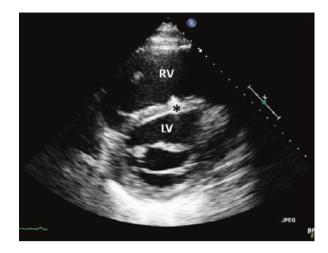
A 2-dimensional echocardiogram image showing dilation of the right ventricle (*RV*) and flattening of the intraventricular septum (*) due to right ventricular pressure and volume overload. *LV* left ventricle
